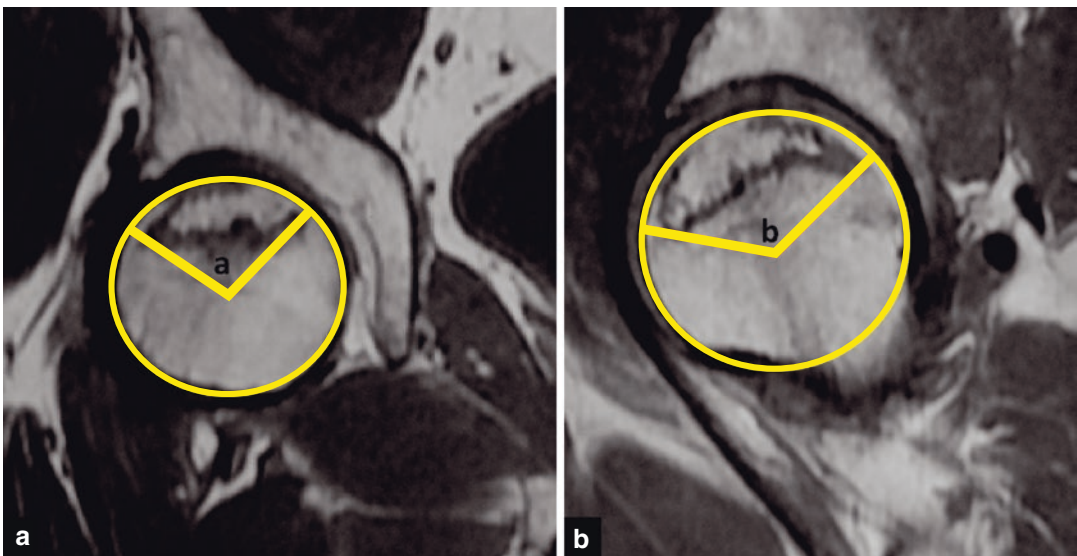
Coronal (a) and sagittal (b) T1-wt MR images used in determining the necrotic extent index of the femoral head
